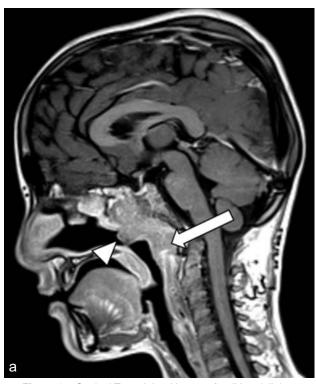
Sagittal T1-weighted image after IV gadolinium administration through the head and neck showing enhancing soft tissue thickening (arrow) almost completely obliterating the nasopharynx (arrowhead).
